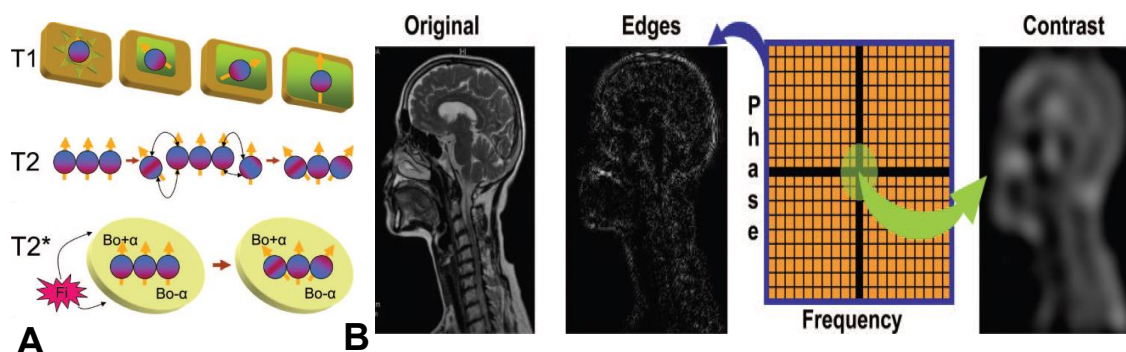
Figure and content for figure legend adapted from Currie S, Hoggard N, Craven IJ, Hadjivassiliou M, and Wilkinson ID. Understanding MRI: basic MR physics for physicians. Postgraduate medical journal 89: 209-223, 2013 ; Bitar R, Leung G, Perng R, Tadros S, Moody AR, Sarrazin J, McGregor C, Christakis M, Symons S, Nelson A, and Roberts TP. MR pulse sequences: what every radiologist wants to know but is afraid to ask. Radiographics : a review publication of the Radiological Society of North America, Inc 26: 513-537, 2006. Used with permission.
